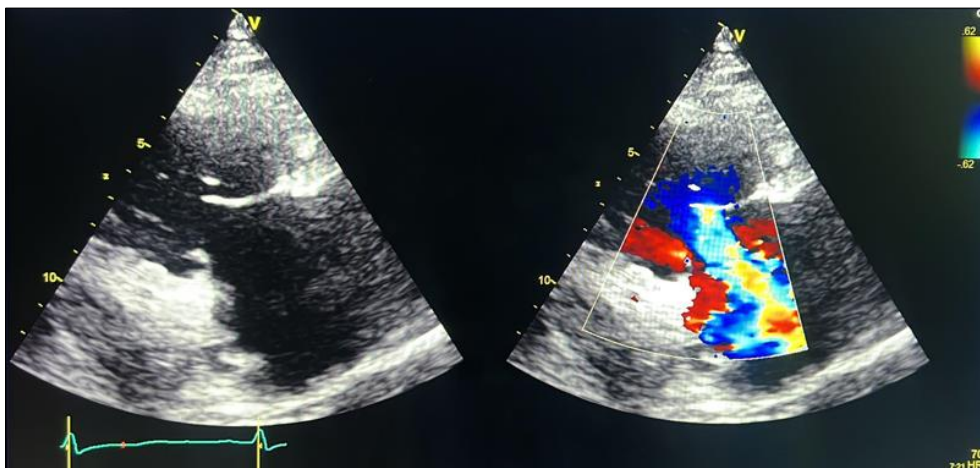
Echocardiographic image in parasternal long-axis view centered on the right chambers in two-dimensional mode and color Doppler showing carcinoid involvement of the tricuspid valve and regurgitation
